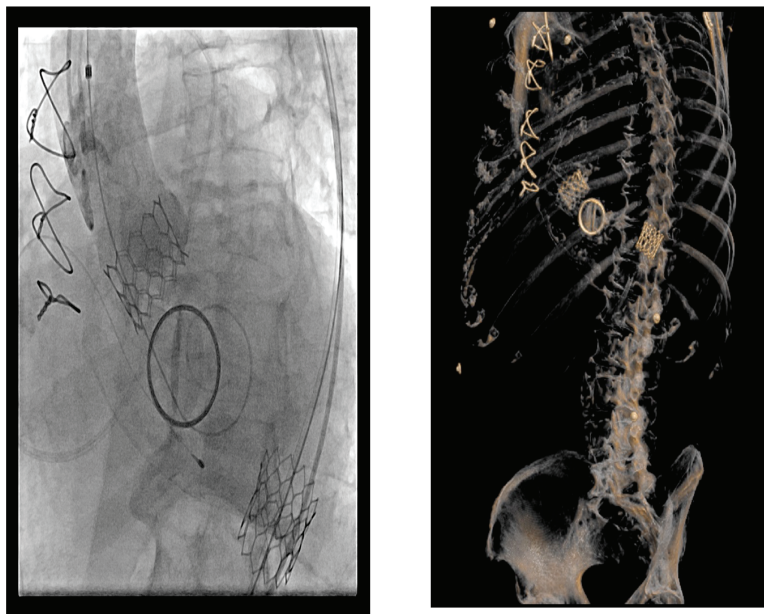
Position of all three valves. A. Angiographic view B. CT scan
